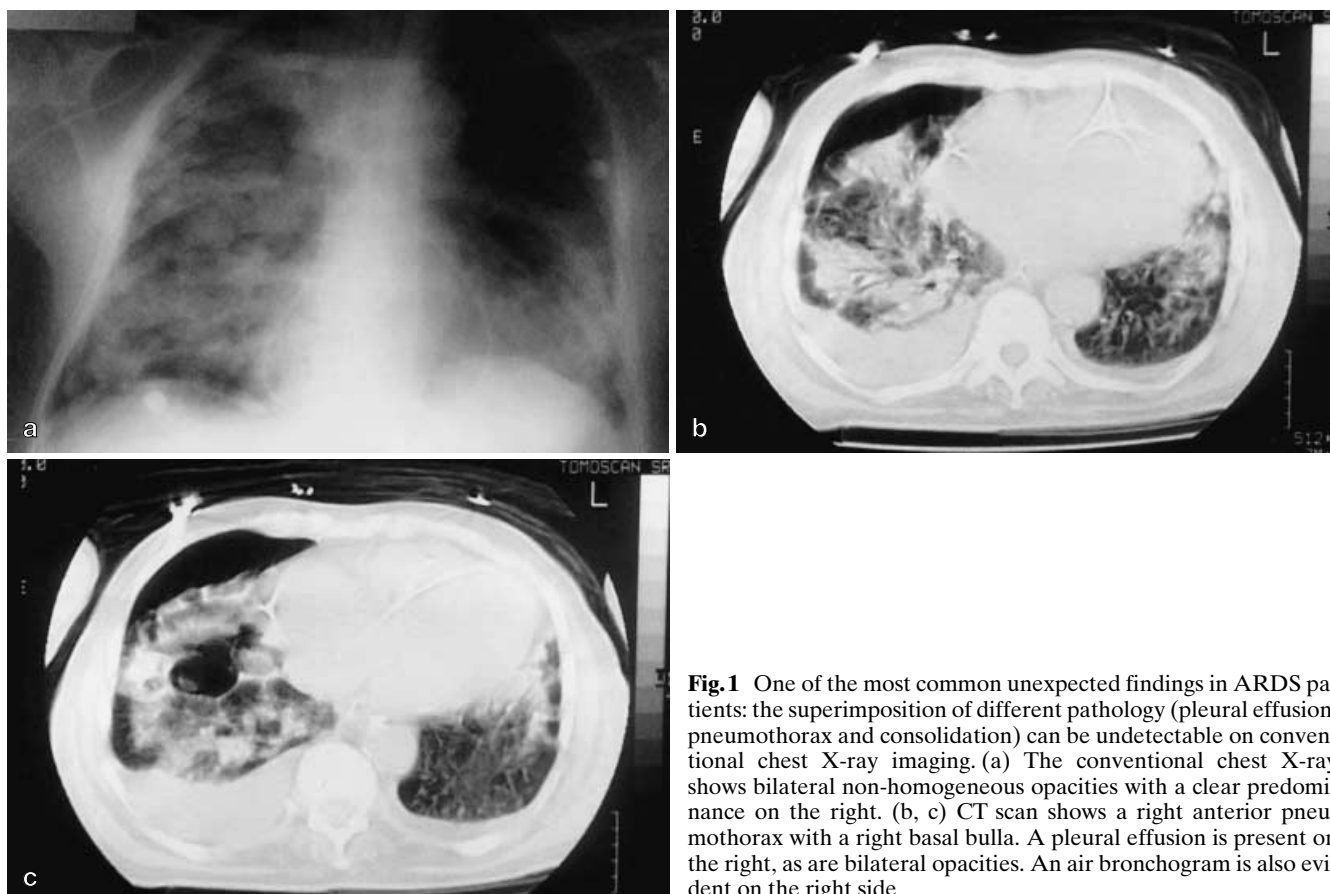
One of the most common unexpected findings in ARDS patients: the superimposition of different pathology (pleural effusion, pneumothorax and consolidation) can be undetectable on conventional chest X-ray imaging. (a) The conventional chest X-ray shows bilateral non-homogeneous opacities with a clear predominance on the right. (b, c) CT scan shows a right anterior pneumothorax with a right basal bulla. A pleural effusion is present on the right, as are bilateral opacities. An air bronchogram is also evident on the right side
